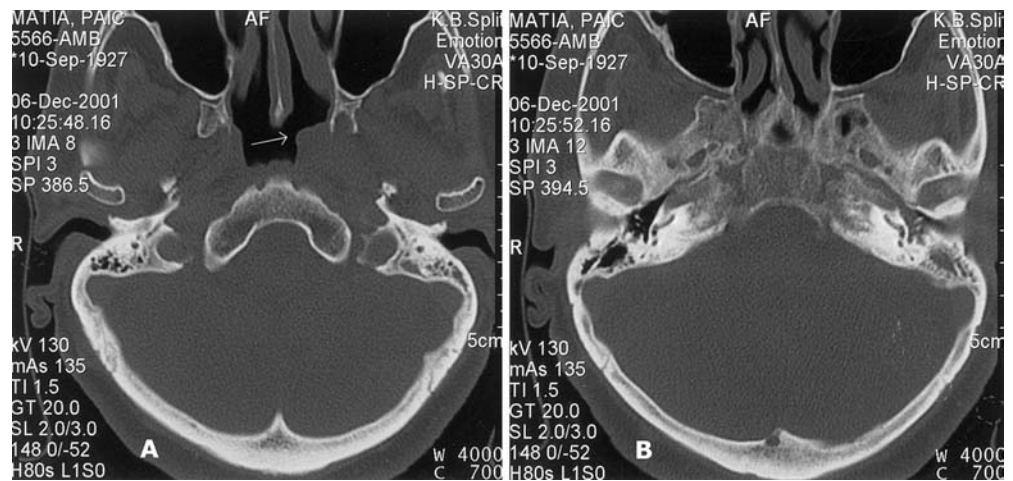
A Nasopharyngeal and temporal bone CT scan showing an expansive tumor of the lateral left nasopharyngeal wall, B tumor's progression to the left middle ear
